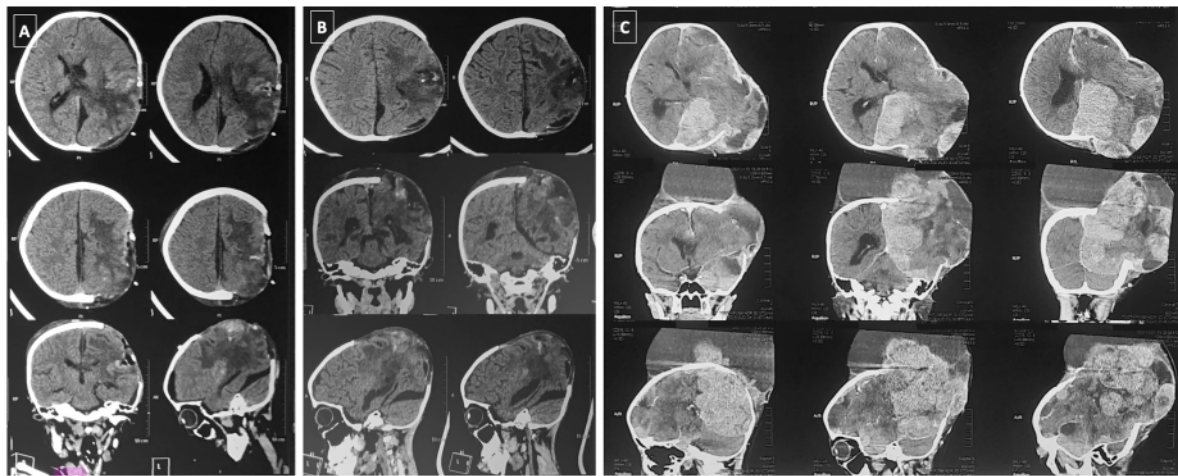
CT Scan imaging progression of the tumor mass after the first surgical procedure. CT Scan imaging early post-operative (A) shows a hemorrhage in the surgical bed without any residual mass. CT Scan imaging 5-days later (B) shows growth of the tumor mass with perifocal edema. CT Scan imaging a month after the first surgery (C) shows aggressive growth of the tumor mass exceeding the calvaria with multi-density in the imaging.
